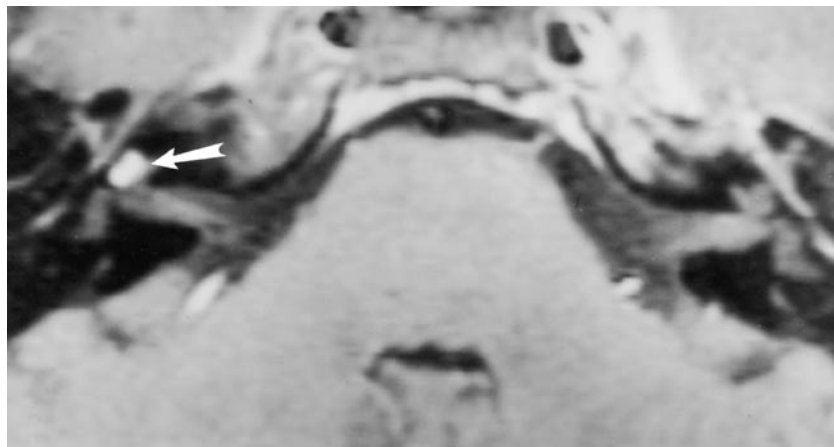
Gadolinium-enhanced MRI demonstrates an intralabyrinthine cochlear schwannoma (arrow) in a patient with the audiogram in Fig. 11.9
